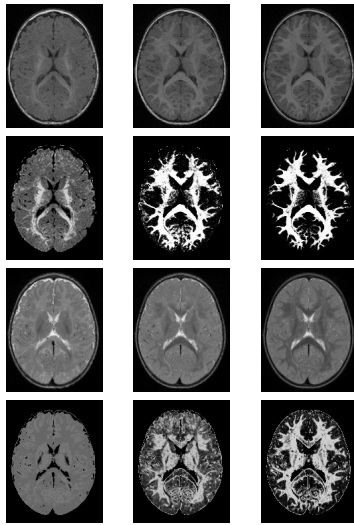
T1W (first row) and T2W (third row) MR images of a single subject and their corresponding T1W (second row) and T2W (fourth row) white matter probability maps, scanned approximately at ages 6, 12, and 24 months (from left to right).
